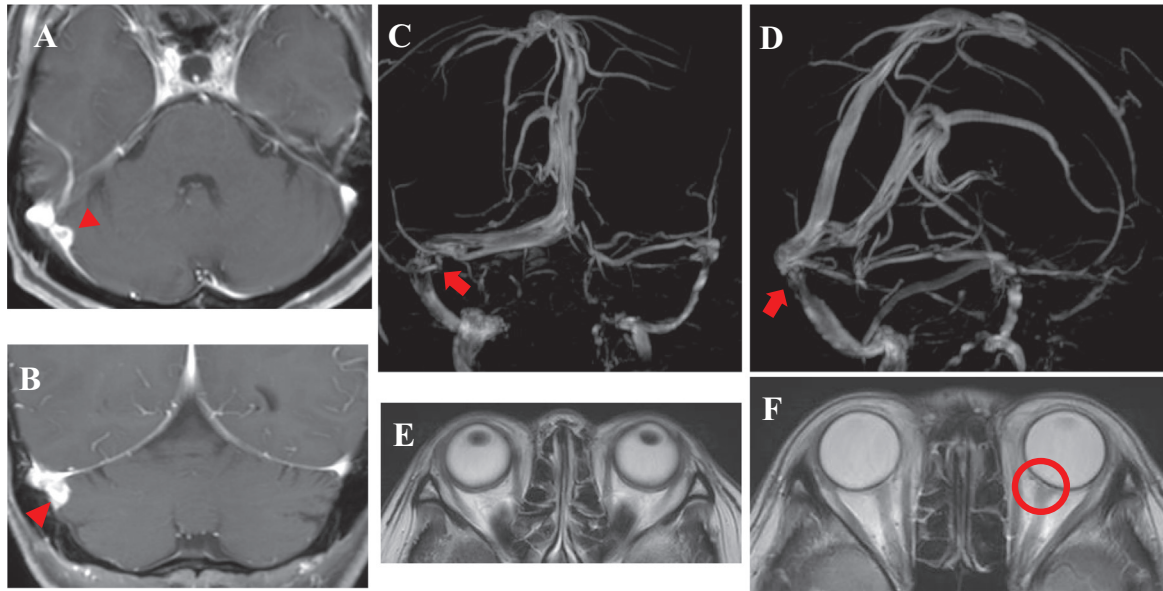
T1-weighted Gd-DTPA-enhanced axial (A) and coronal (B) MRI show the reduction of the tumor on the transverse sinus-sigmoid sinus (arrowheads) 10 months after embolization. MRV showing the improvement of severe stenosis (arrows) at the junction of the right transverse sinus and the sigmoid sinus (C and D) 10 months after embolization. MRI showing the improvement of eye protrusion (E), tortuosity of the bilateral optic nerve, expansion of the surrounding cerebrospinal cavity, and protrusion of the optic disk (F). MRI: magnetic resonance imaging; MRV: magnetic resonance venography
